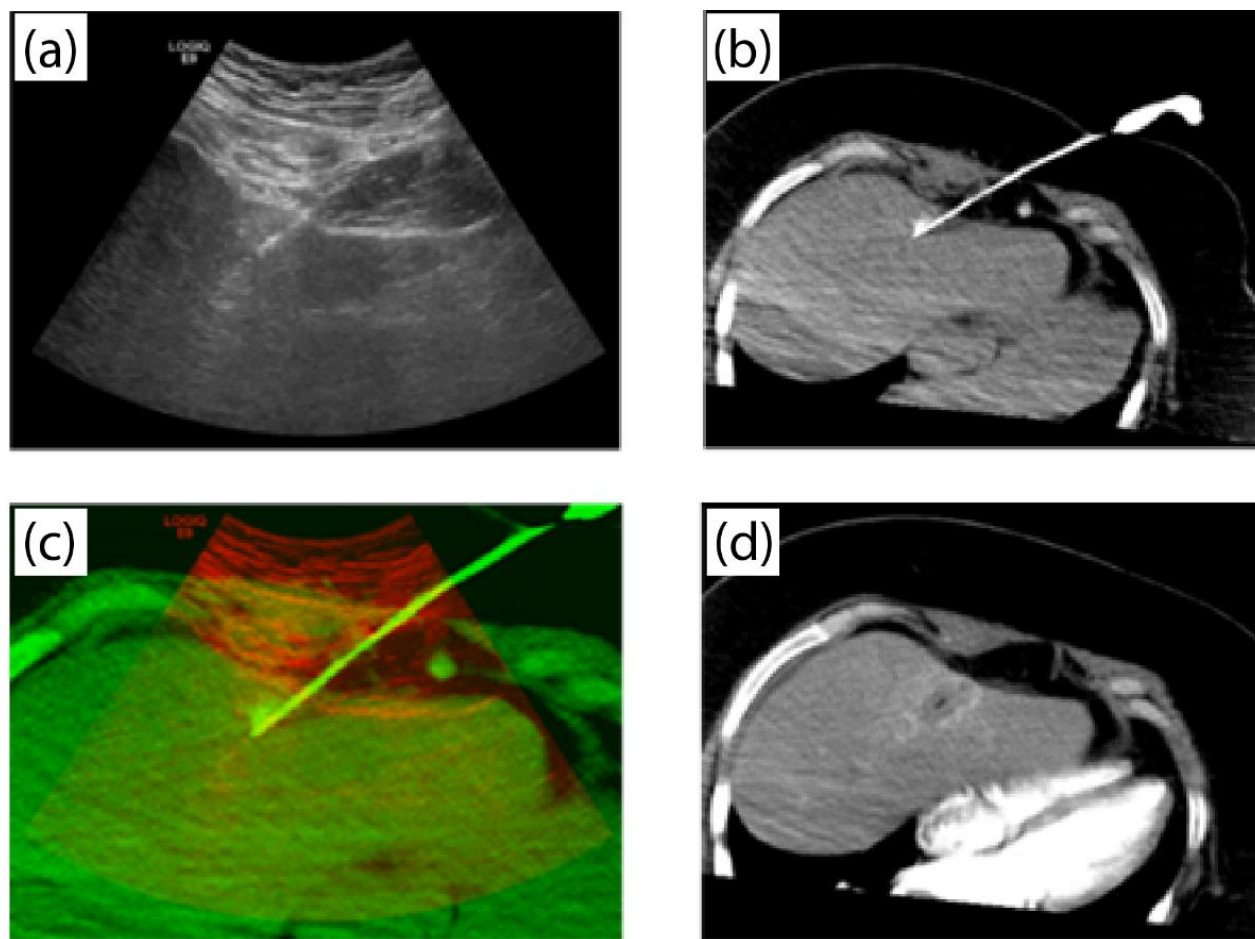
An example of US B-mode – CT registration result for a second patient (a) US B-mode prior to ablation with antenna visible. (b) Co-located CT virtual slice. (c) The registered CT virtual slice after affine transformation in green transposed onto the red.
